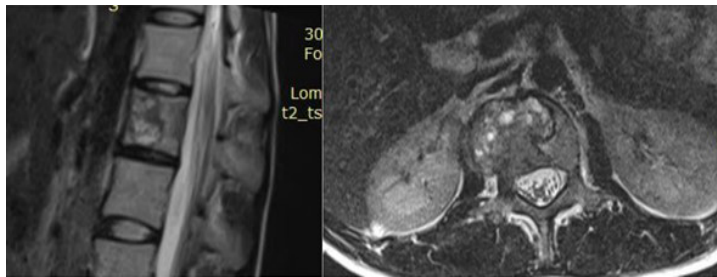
Patient's first sagittal and axial MR images
